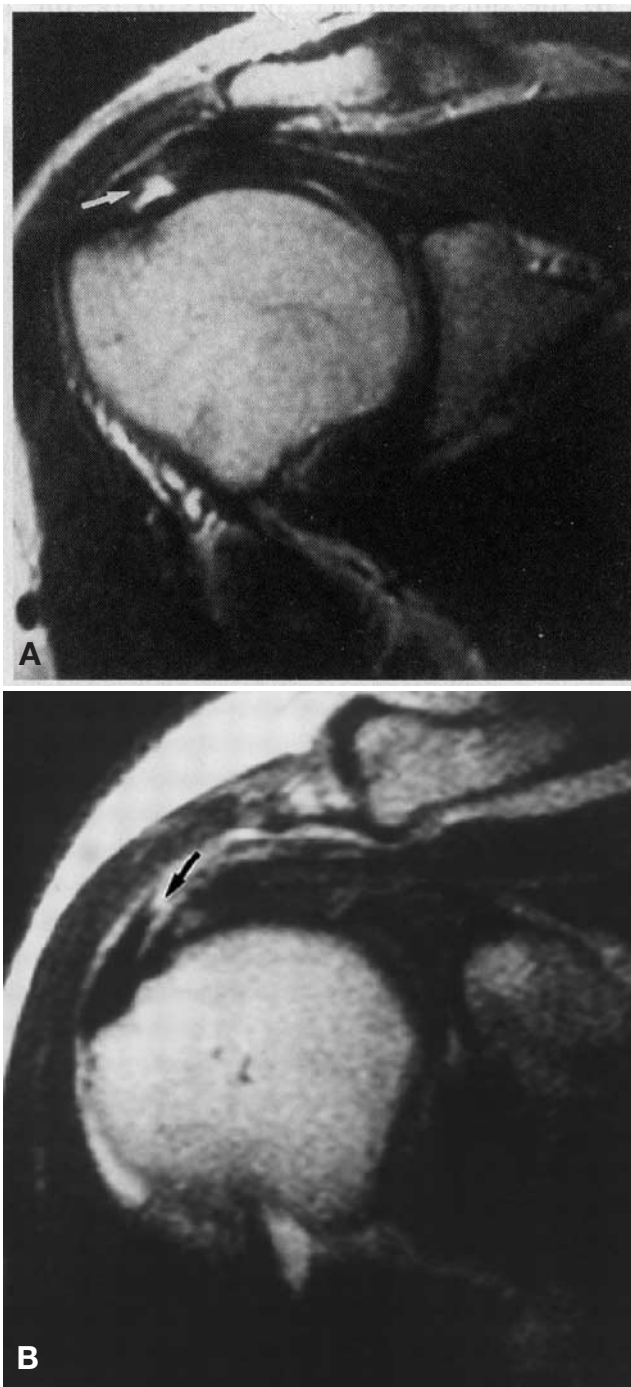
A, T2-weighted oblique coronal image showing a deep partial-thickness tear (arrow) involving the articular surface of the cuff. B, T2-weighted oblique coronal image showing an irregular oblique tear (arrow) involving the bursal side of the cuff. Reprinted with permission from Herzog et al.³⁹
